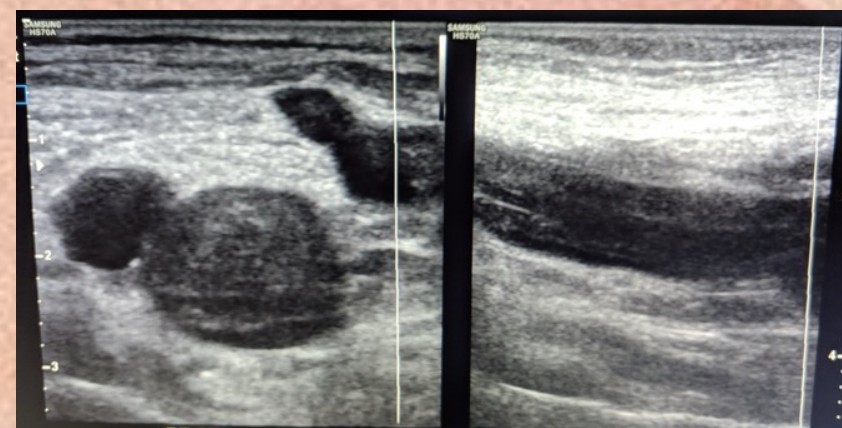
Ultrasound shows extensive echogenic thrombus within the distended and non-compressible vein.
